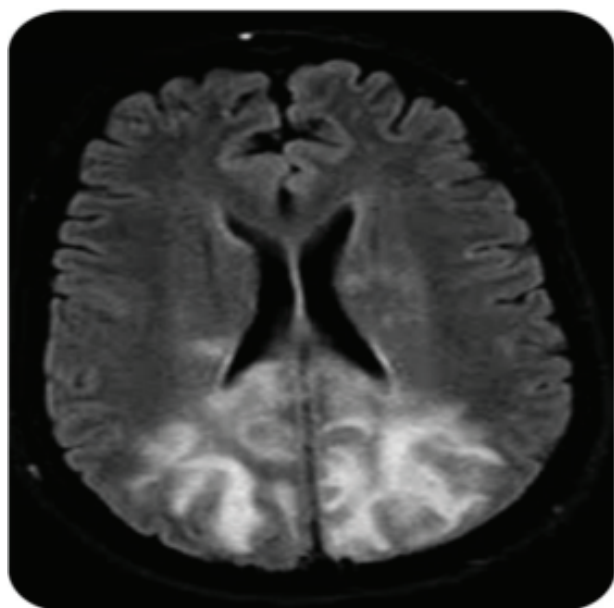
Axial FLAIR MRI image demonstrating bilateral subcortical hyperintensities predominantly in the parieto-occipital lobes, consistent with vasogenic edema seen in posterior reversible encephalopathy syndrome (PRES).
